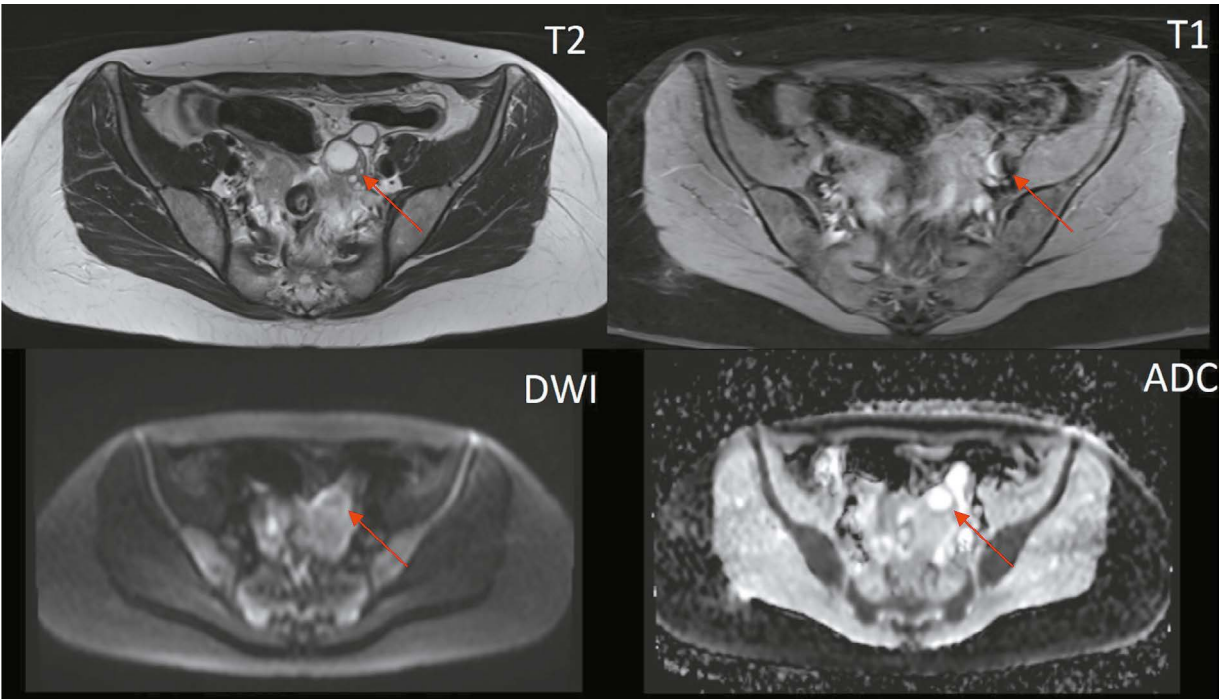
Pelvic magnetic resonance imaging (axial view). The left ovary shows follicles and a simple cyst (O-RADS 1, red arrow).
